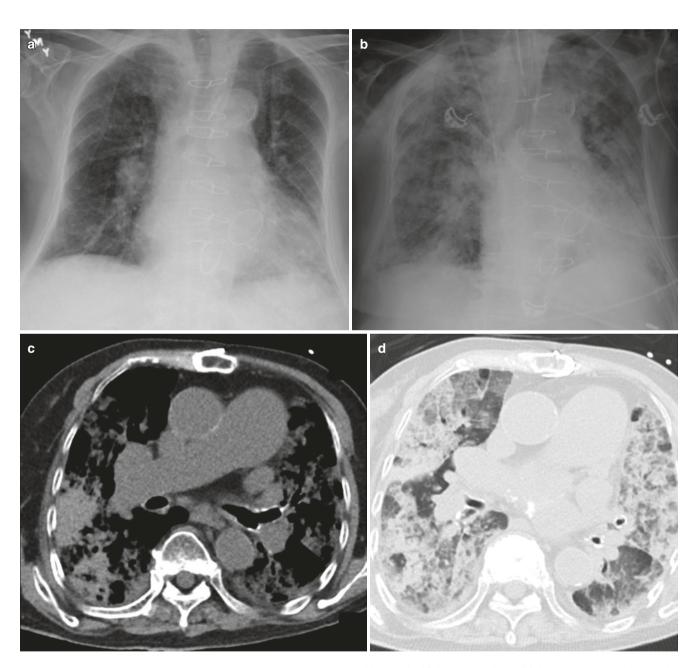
Diffuse alveolar hemorrhage from parainfluenza virus infection. (a, b) AP chest radiographs taken a day apart, show rapidly progressing diffuse opacities in both lungs with no significant pleural effusion. (c) Axial non-contrast CT image shows
